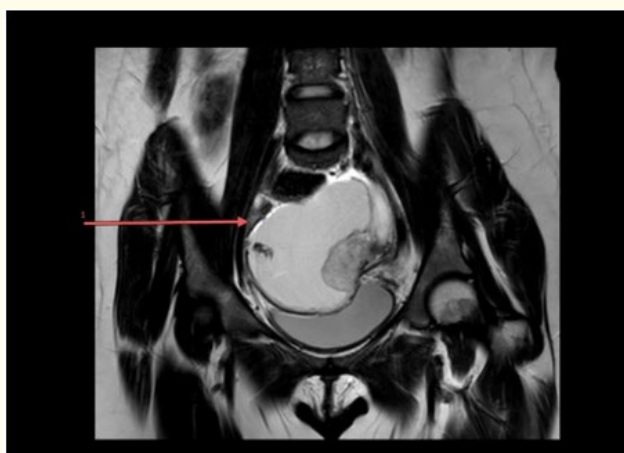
Pelvic MRI, coronal T2 sequence, showing the right ovary with a pseudo claw sign appearance with the mass.
